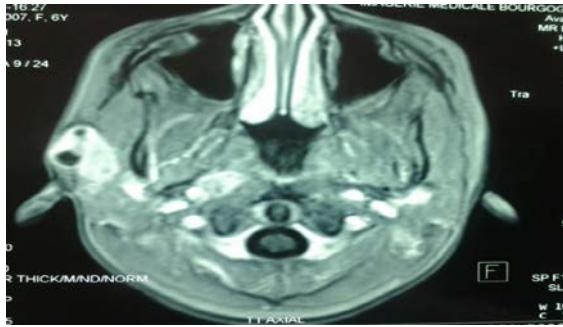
MRI image of right parotid swelling.
